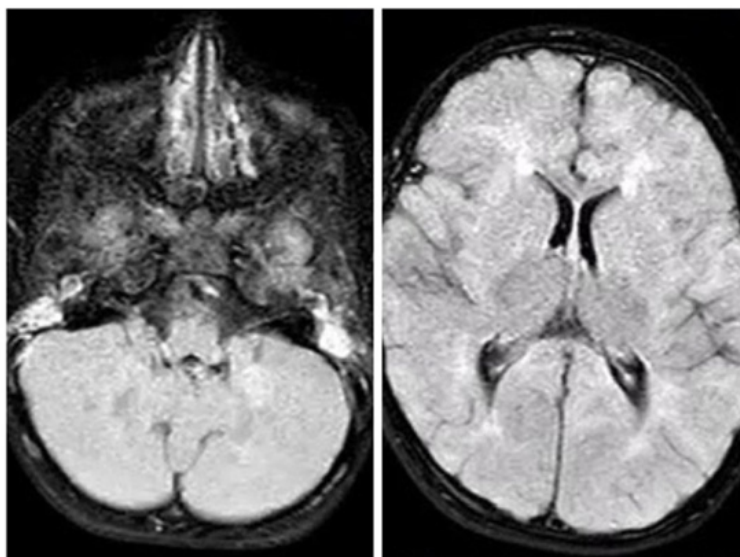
Axial 2 FLAIR cuts of brain MRI showing Diffuse severe bilateral periventricular FLAIR matter hyperintense changes, and FLAIR white matter hyperintense changes in bilateral centrum semiovale and cerebellar white matter, reflecting gliosis versus leukomalacia.
